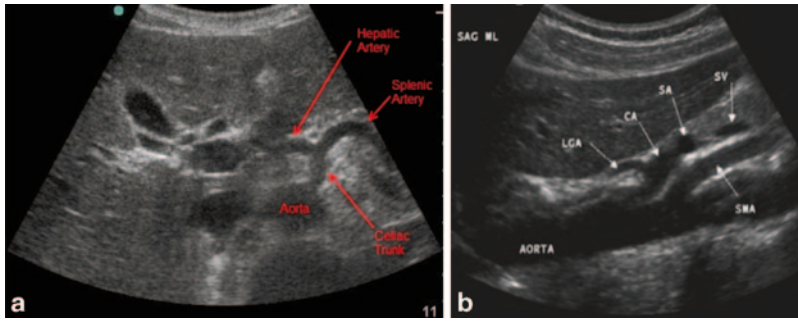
a During sonography, look for the vertebral body in the transverse plane. The aorta and inferior vena cava (*IVC*) will be anterior to it. The *IVC* is compressible. The aorta will be anechoic with a pulsating circle. In the proximal aorta, the celiac trunk can be seen with its branches (seagull sign—hepatic and splenic arteries are the wings).
